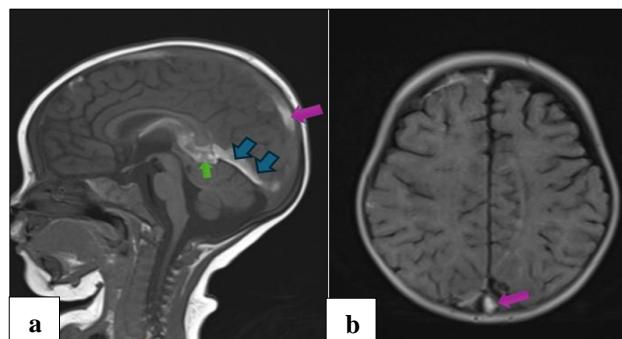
Brain MRI showing (a) sagittal T1-weighted image without gadolinium injection, and (b) axial FLAIR sequence, demonstrating hyperintense signal within the superior sagittal sinus (pink arrow), straight sinus (blue arrow), and vein of Galen (green arrow).
